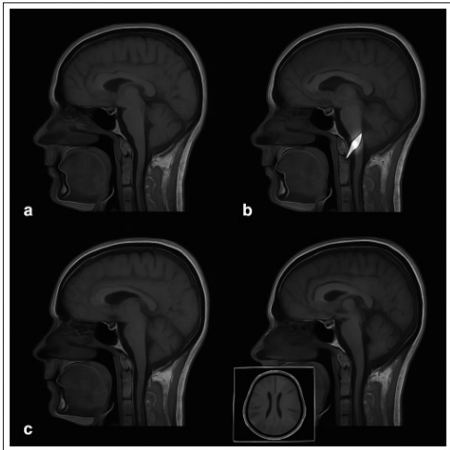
Multisequence Sagittal Brain MRI (Plain and Post-Contrast T1 Images)
